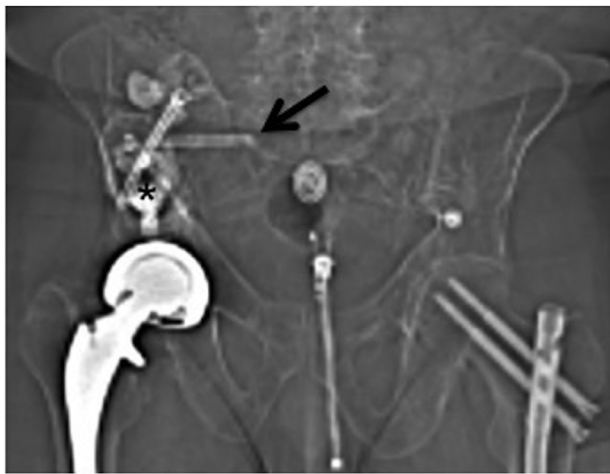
(Patient 2) Scout topogram image from computed tomography within the first month postprocedure, shows a limited over-view of the procedural implants with anterior projections of the iliac and sacral fixation screws (arrows) and cement osteoplasty (*) without complication.
